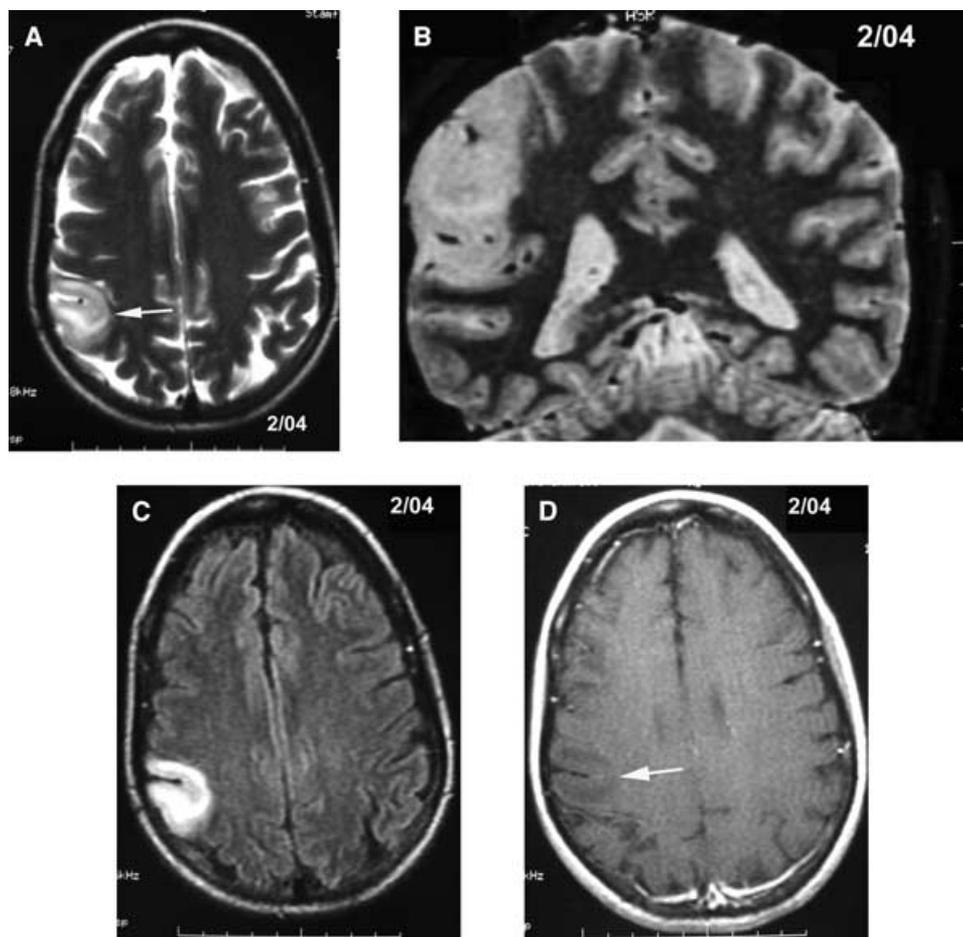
Preoperative brain MRI of Patient 1. A) T₂-weighted axial image with discrete right parietal area of intraparenchymal increased signal (arrow). The same abnormality is seen in: B) T₂-weighted coronal, C) Axial FLAIR, and D) Axial T₁ with gadolinium (arrow).
